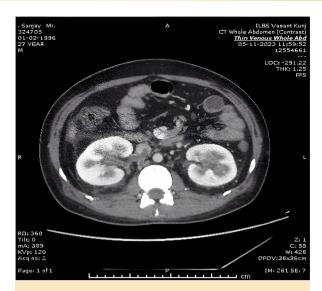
CT angiography showed right renal vein thrombosis with IVC extension.
